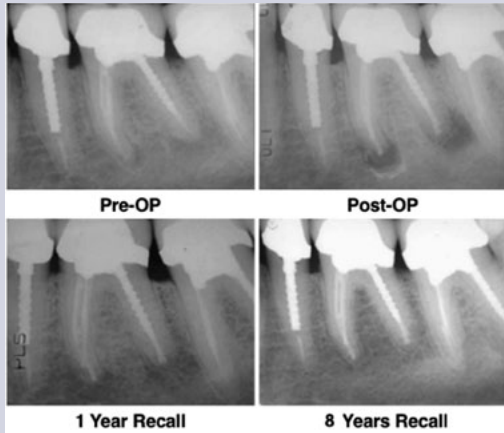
An 8-year recall of #19 treated by microsurgery. Notice the complete resolution of the PAR and total regeneration of the periapical tissues.
